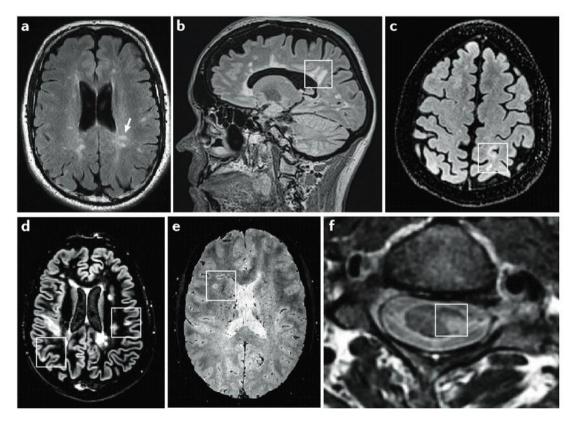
MRI features typical of MS a) Dawson finger (arrow), visible as ovoid, hyperintense, periventricular lesions perpendicular to the body of the lateral ventricle and/or the callosal junction, in a FLAIR image. b) Dawson finger (inset) in a sagittal FLAIR image. c) An S-shaped juxtacortical lesion (inset) in an axial FLAIR image. d) Cortical lesions (inset) shown on a double inversion recovery (DIR) image e) The central vein sign (inset), visible on magnetic susceptibility weighted imaging (T2* axial image). f) Eccentric spinal cord lesions (inset) typical of multiple sclerosis, shown in a T2-weighted axial image. (Geraldes et al., 2018a).
